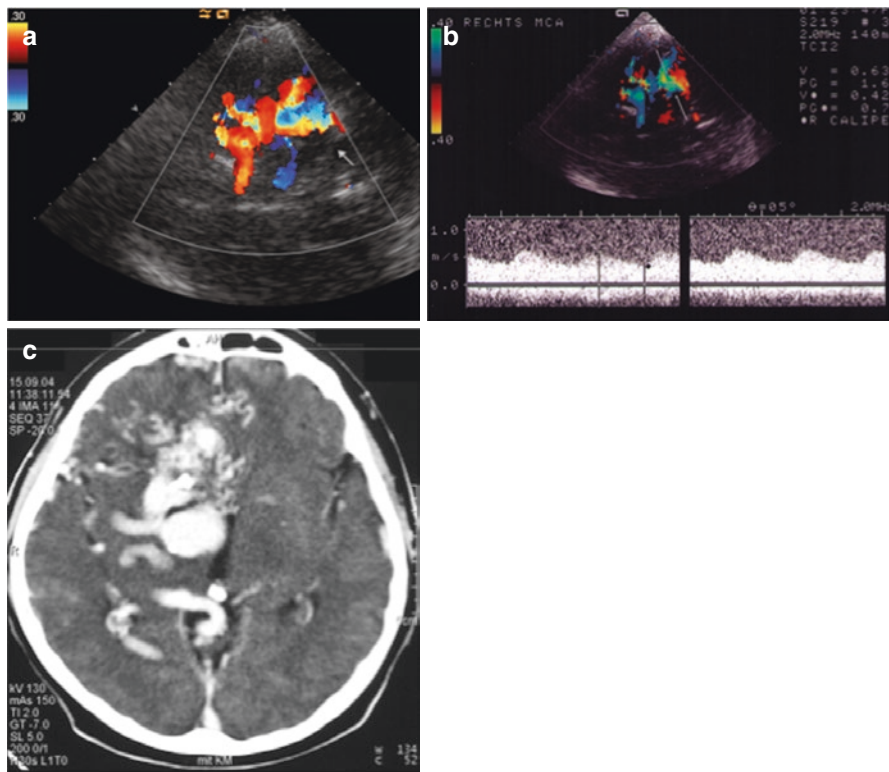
Visualization of an extensive basal arteriovenous malformation with color-coded duplex sonography
